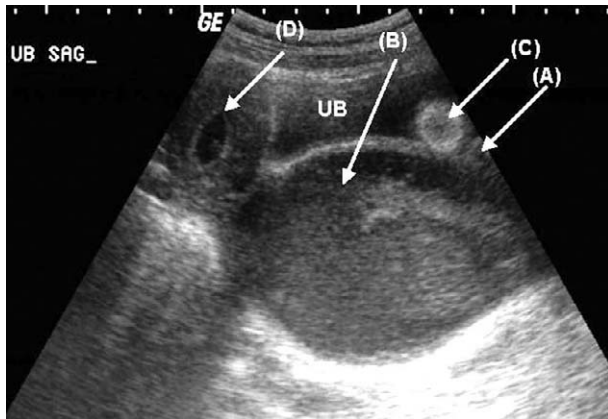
Longitudinal sonogram shows the urethra (A) compressed by hematocolpos (B). The Foley balloon (C) is in place of the urinary bladder (UB). The uterine cavity (D) is filled with fluid, representing hematometra.
